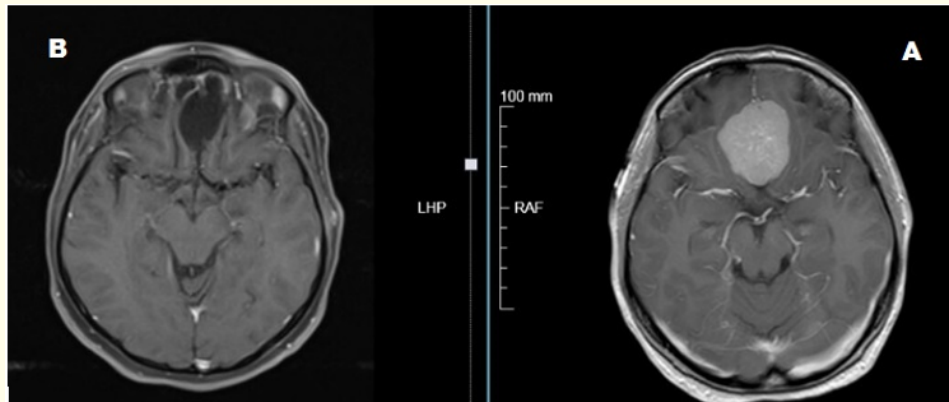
Axial MRI cuts show a midline supra-sellar meningioma (A) with post-operative image shows gross total resection(B) via a sub-frontal approach.
